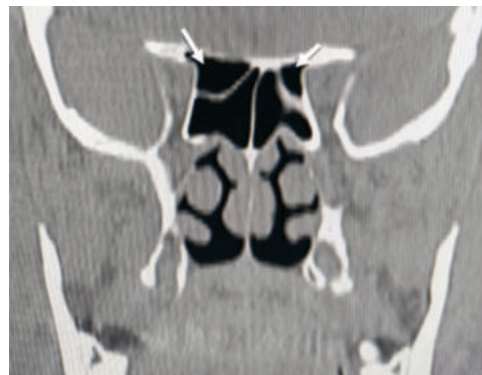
CT coronal image showing Bilateral Onodi cells
